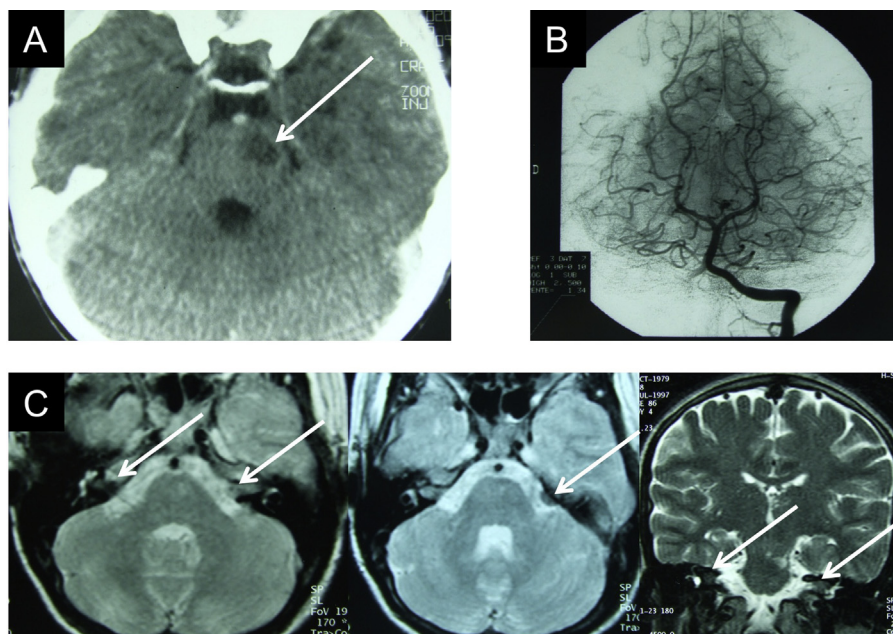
(A) CT-scan at the onset of hemiplegia revealing a left brainstem ischemic stroke. An arrow is indicated the region of the evolving stroke, (B) normal posterior circulation arteriography. (C) Brain MRI at age 17. Arrow denotes a cerebellopontine angle tumor on the left and bilateral intracanalicular signal abnormalities.
